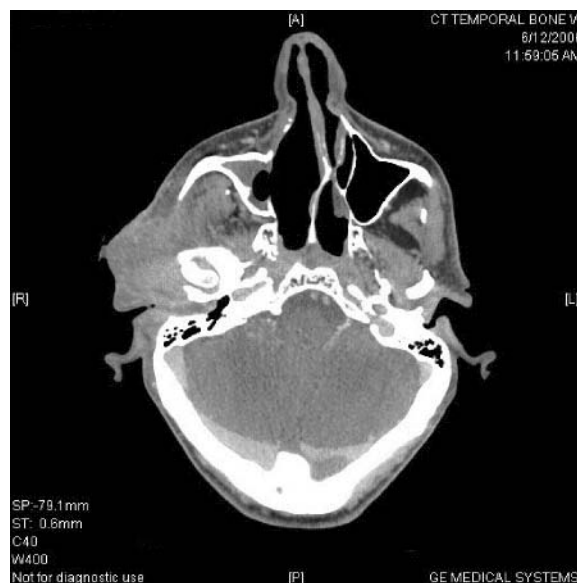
Axial CT scan demonstrating neoplastic invasion of the temporal bone by SCCA of the parotid gland (pt at UMC-Lafayette)
